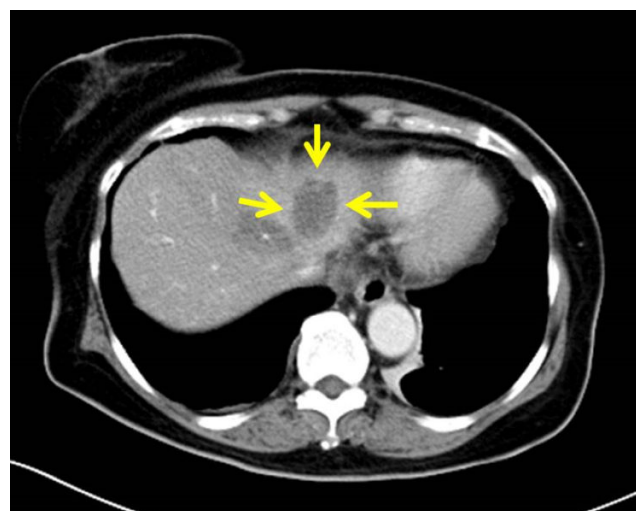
Enhanced CT image of the patient, 8 days after IRE ablation. The tumor showed areas of low density, as indicated by the arrows.
